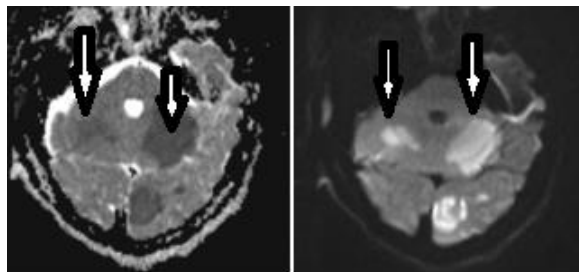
Diffusion MRI of the case with ADC map (A) and b-1000 image (B) shows bilateral dentate nucleus lesions of the cerebellum (arrows).
